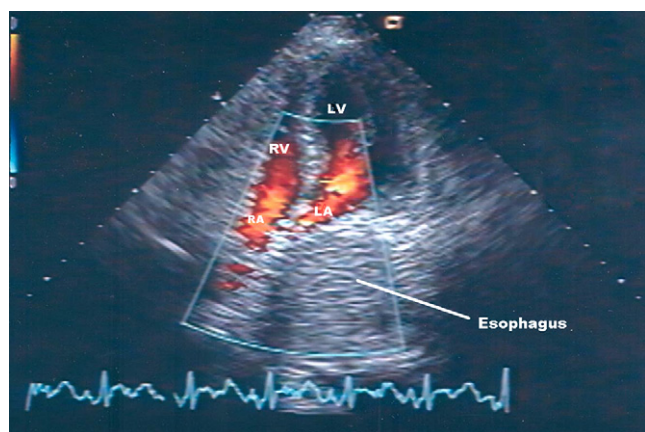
Transthoracic echocardiogram, showing left atrial compression from an extrinsic lesion, as well as a thrombus in the left ventricle. The diameter of the left atrium is 1.1 cm.
